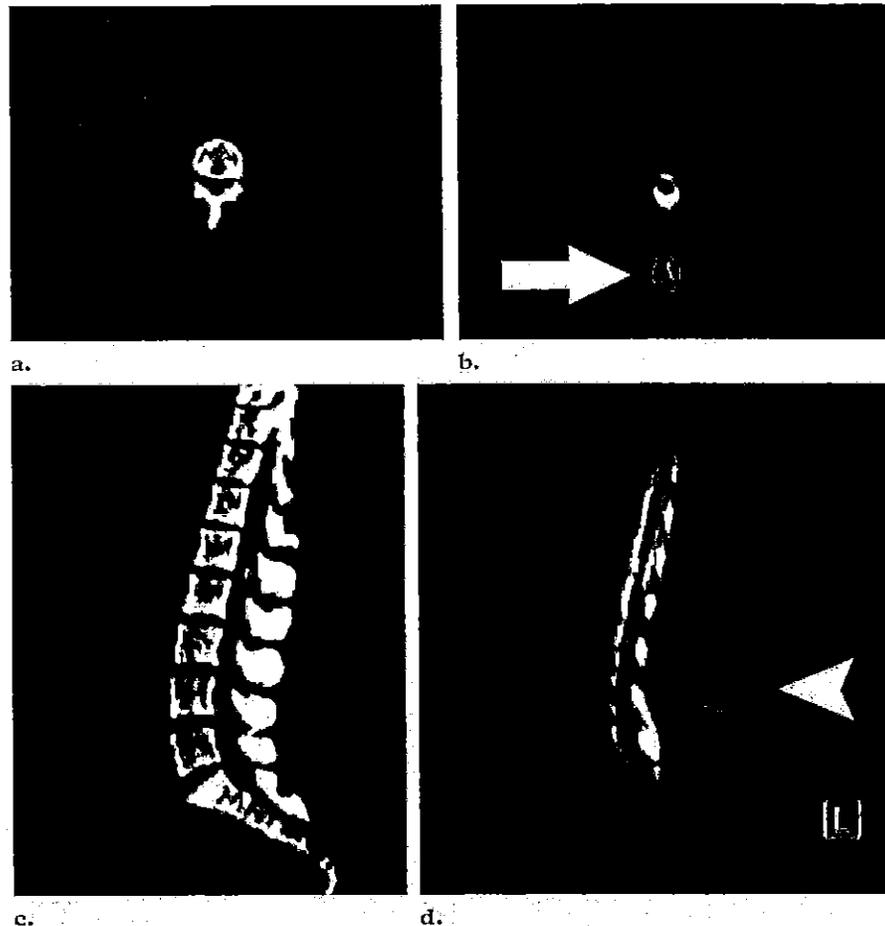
Detection of a cerebrospinal fluid leak with SPECT/CT in a patient with a lumboperitoneal shunt for pseudotumor cerebri who experienced headaches. There was clinical suspicion of a cerebrospinal fluid leak. Axial (a, b) and sagittal (c, d) images from CT (a, c) and scintigraphy (b, d) show a cerebrospinal fluid leak (arrow in b, arrowhead in d), which is not at the site of radiotracer injection and extends posteriorly at the lower lumbar spine level.
